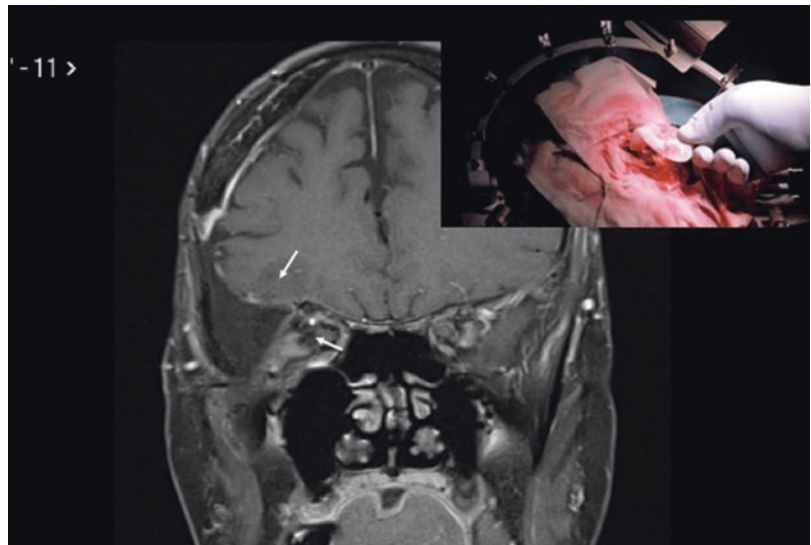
Computer tomography (CT) image of the onlay-type FRC-bioactive glass implant in the temporal area of skull (courtesy: Professor Kalle Aitasalo, Turku University Hospital, Finland)
